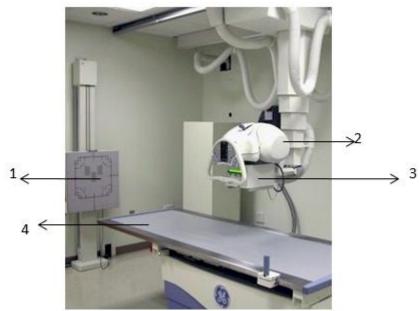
X-ray plane image at Columbia Asia Hospital in Medan
